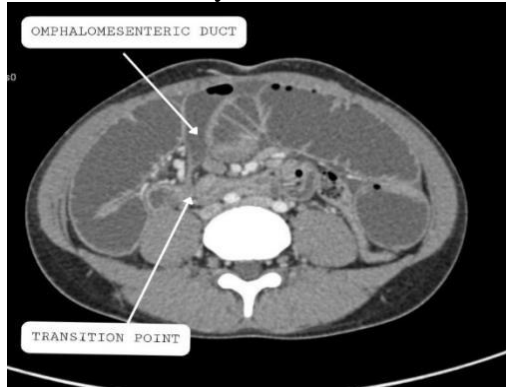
CT abdomen showing persistent omphalomesenteric duct
